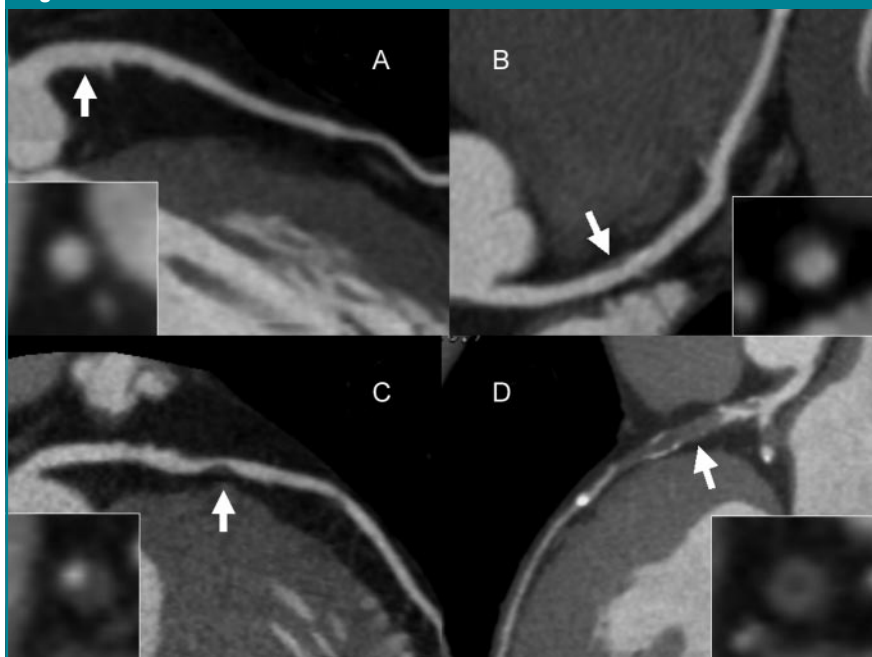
CT angiograms show grading of coronary artery stenosis. In A, no stenosis (0% occlusion) is seen. In B, 1%–49% occlusion is visible. In C, 50%–75% occlusion can be seen. In D, there is more than 75% occlusion. Arrows = stenotic lesions. The magnified areas show cross-sectional views of targeted areas.
